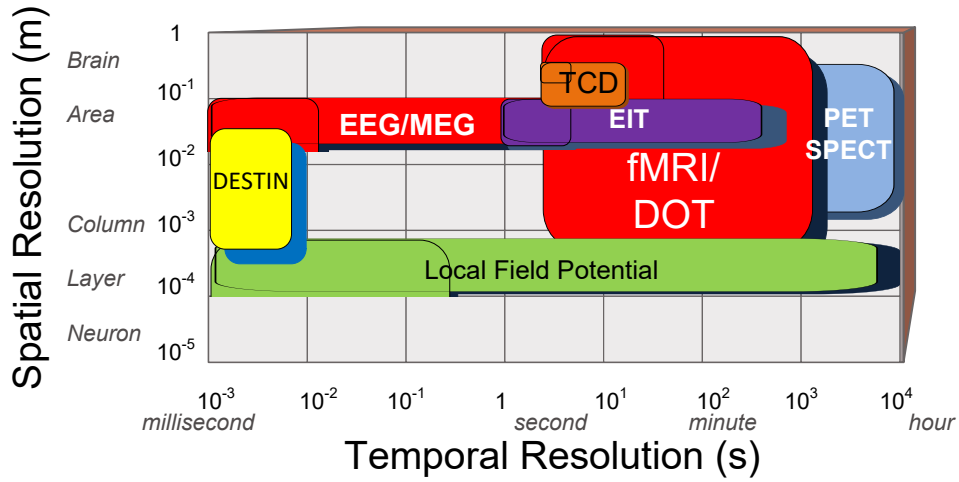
(Top) Temporal and spatial resolution comparison among different imaging modalities, including: Diffuse Optical Tomography (DOT), EEG, Electrical Impedance Tomography (EIT), functional MRI (fMRI), magnetoencephalography (MEG), Positron Emission Tomography (PET), Single-Photon Emission Computed Tomography (SPECT), Transcranial Doppler (TCD). (Bottom) Sagittal and coronal views of the human head with sources (in red) of neurons firing in cortex and electrodes placed on top of the skull. Depicting the concept of source mixing, in which each electrode “sees” more than one source.
